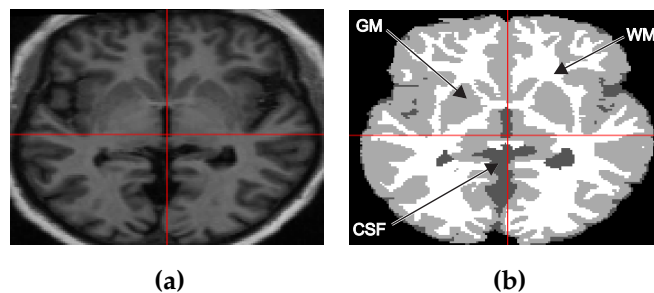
An example of the brain MRI segmentation: (a) Raw brain T_{1w} MRI scan; (b) the segmented image with three labels WM, GM, and CSF.
